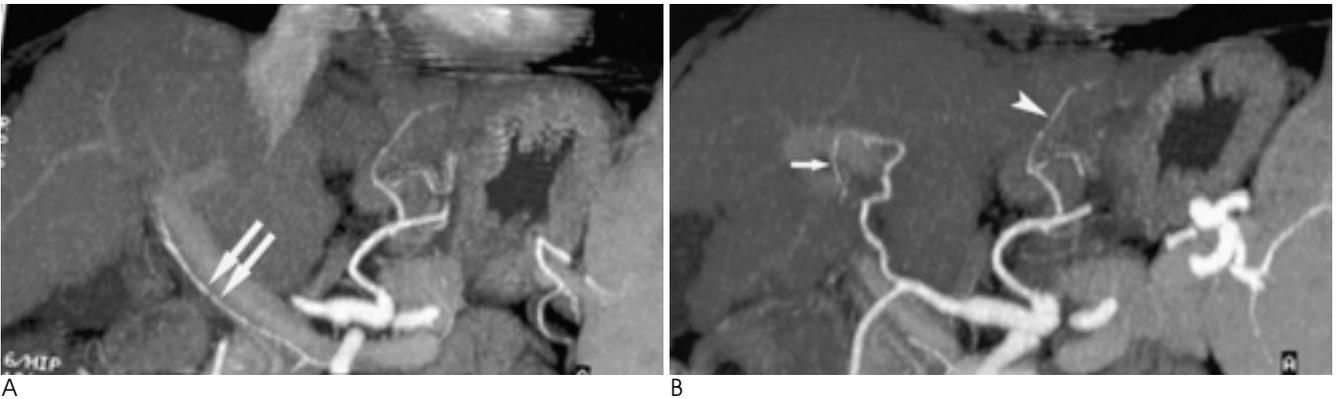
Type VIII of Michels classification. Oblique coronal three-dimensional CT angiograms (A and B) show right hepatic artery (arrows) arising from superior mesenteric artery and accessory left hepatic artery (arrowhead) originating from left gastric artery. 3DCT angiogram (B) demonstrates 2nd branches (small arrow) of hepatic artery, and image quality of 3DCT is estimated as good degree. On conventional angiograms (C and D) hepatic arterial anatomy is type VIII. Because reader A misread accessory left hepatic artery as left gastric artery, he misestimated hepatic arterial anatomy as type III.
